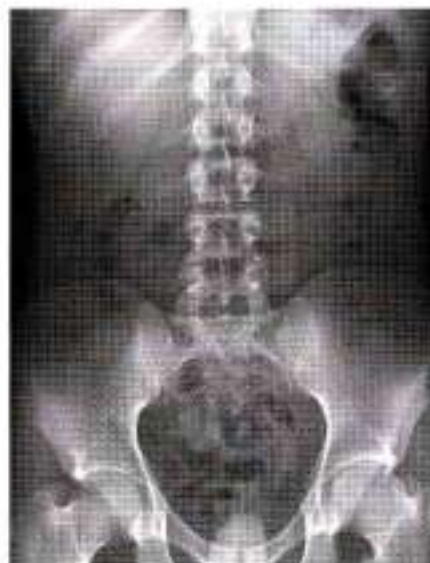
Plain X-ray abdomen
